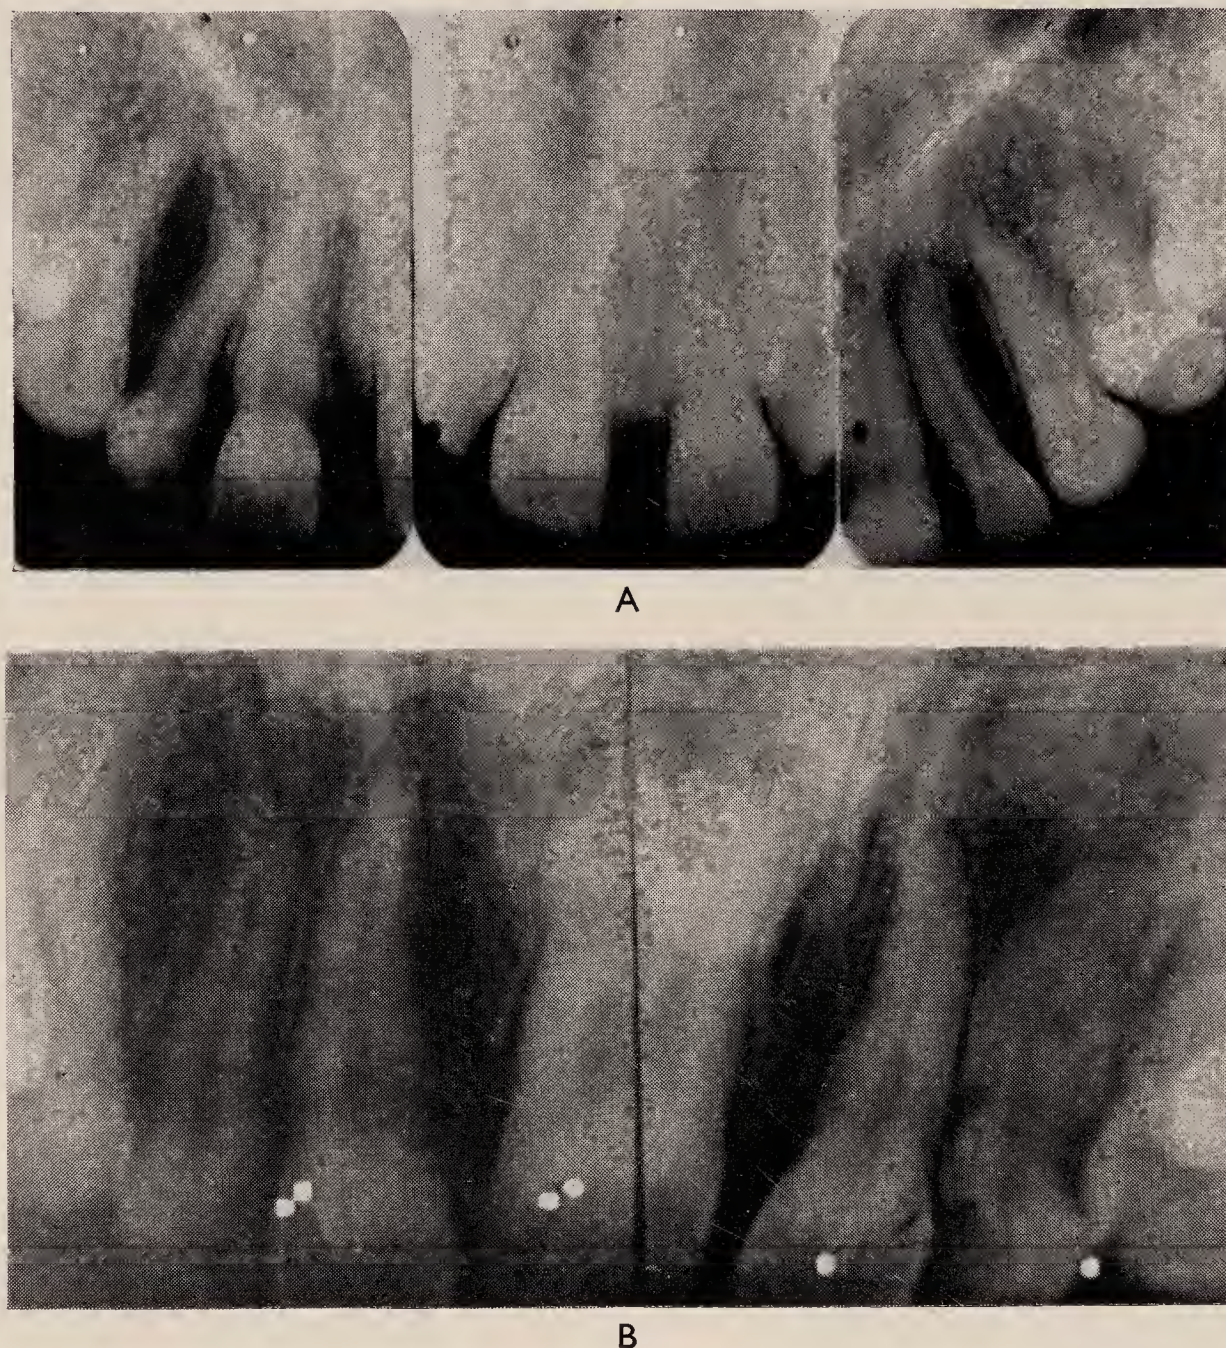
Case 2. Radiographs to show supporting bone A, before treatment, B, after treatment.
